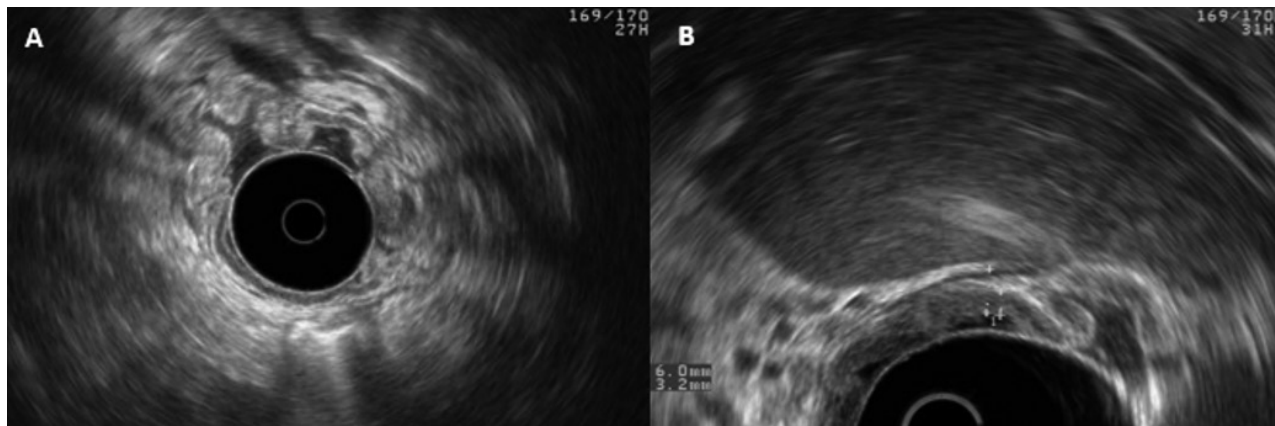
Endoscopic ultrasound photographs showing gastric wall thickening (6mm) due to mucosa expansion (3.2mm) with massive enlargement of gastric body great curvature folds. Submucosa was preserved and antrum was spared.
